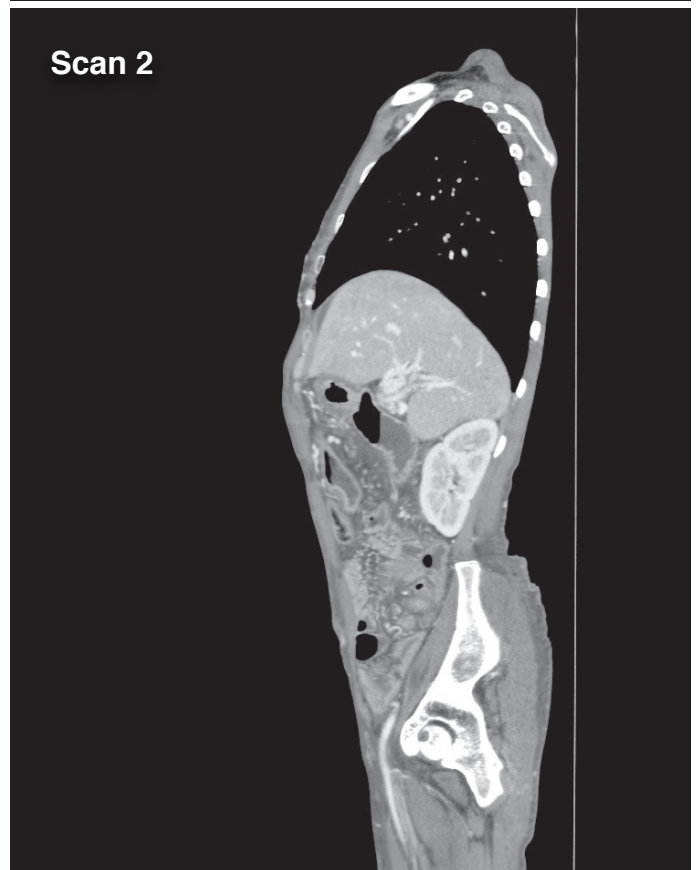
CT abdomen images (venous phase) demonstrating the venous cluster of vessels in the area of the portal vein (cavernous transformation).
